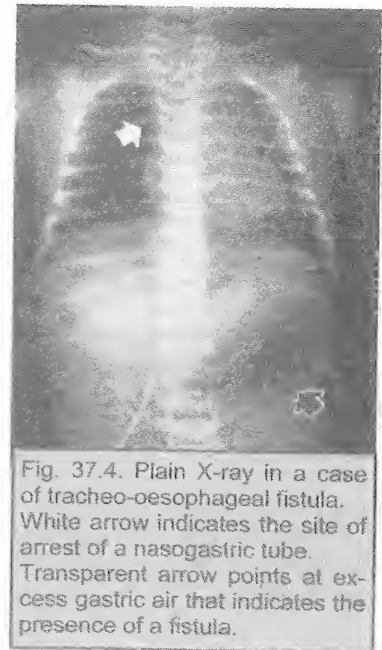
Plain X-ray in a case of tracheo-oesophageal fistula. White arrow indicates the site of arrest of a nasogastric tube. Transparent arrow points at excess gastric air that indicates the presence of a fistula.
